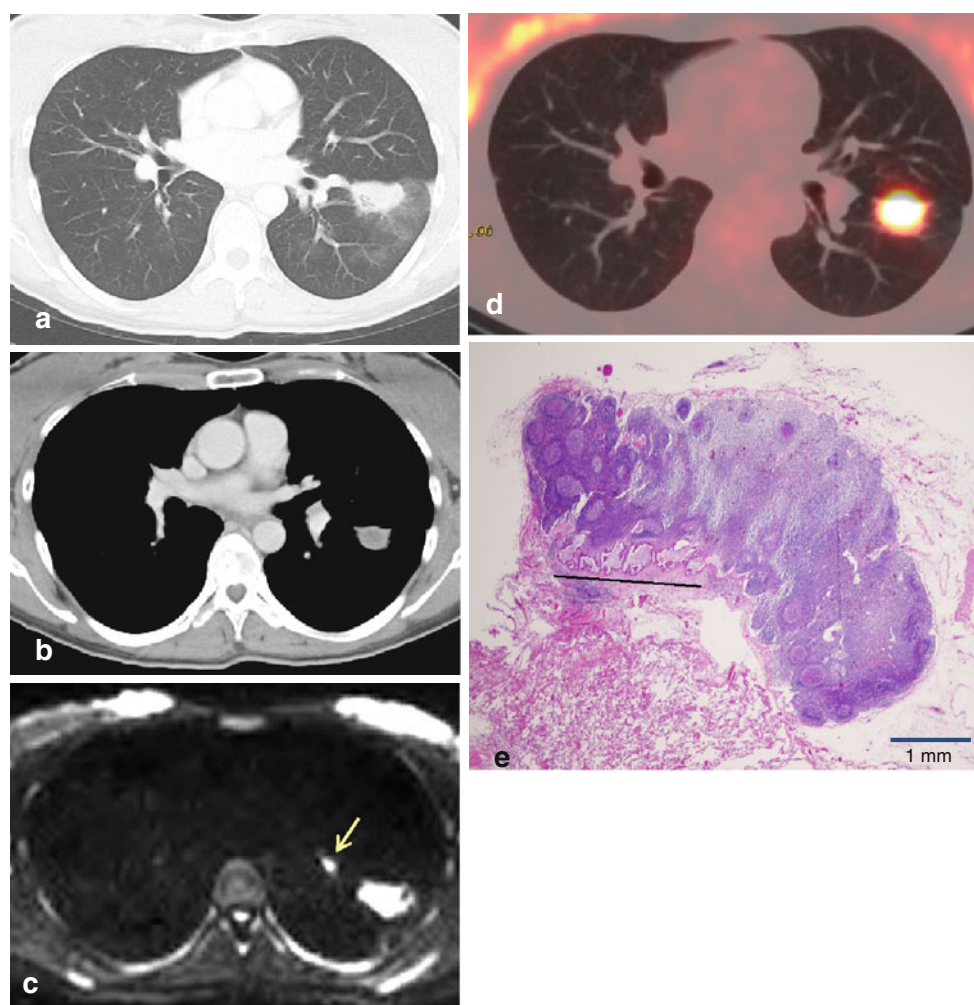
Chest CT (a, b), DWI (c), and PET-CT (d) of one patient with adenocarcinoma. DWI and PET-CT identified the malignant lesion clearly. ADC value of the lung cancer was $1.239 \times 10^{-3} \text{ mm}^2/\text{s}$, and its SUVmax was 11.3. A metastatic lesion (highlighted by an
